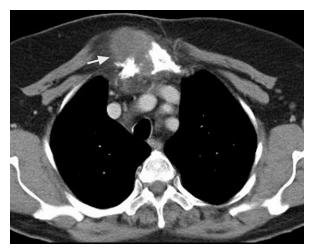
Computed tomogram shows an osteolytic lesion with discrete calcification in the bone marrow of the upper sternum.
